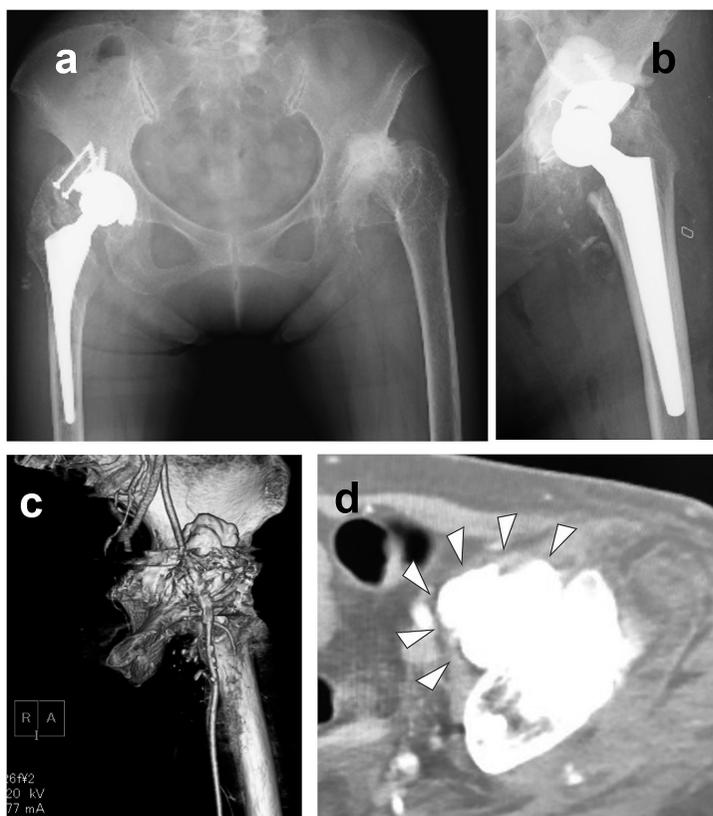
Radiographs before first revision surgery
